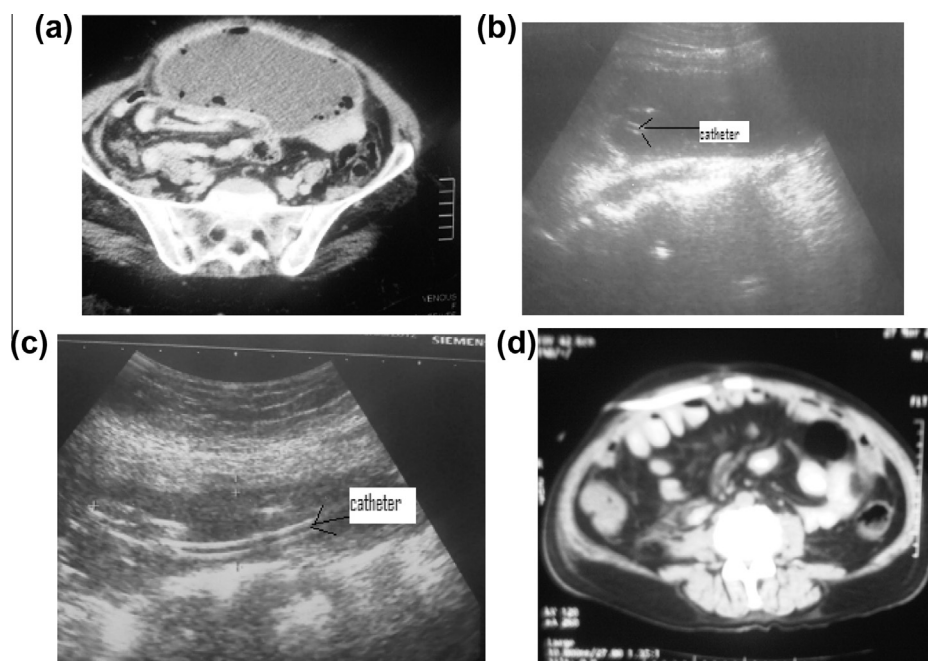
65 Year old woman presented with high fever and pain and tenderness at the lower abdomen with diarrhea. (a) Contrast enhanced CT scan for the pelvis showed pericolic encysted collection with enhanced capsule and few air bubbles. Ultrasound guided access and placement of 8 Fr. Polyurethane catheter arrow. (b) Gradual reduction of catheter output to less than 10 ml/24 h and clinical improvement in terms of pain and fever and normal leukocytic count, ultrasound exam. (c) Showed resolution of the collection and confirmed by CT scan (d).
